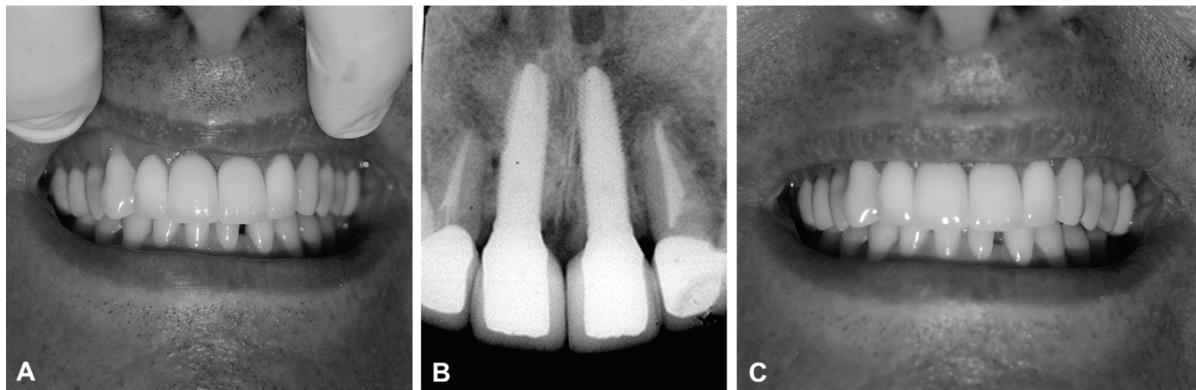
A: postoperative clinical gingival margin contour and papilla after cementation of four metal-free crowns, B: postoperative radiographic control 32 months after the first and 29 after the second implant surgery, and C: clinical aspect after 29 months of follow-up
